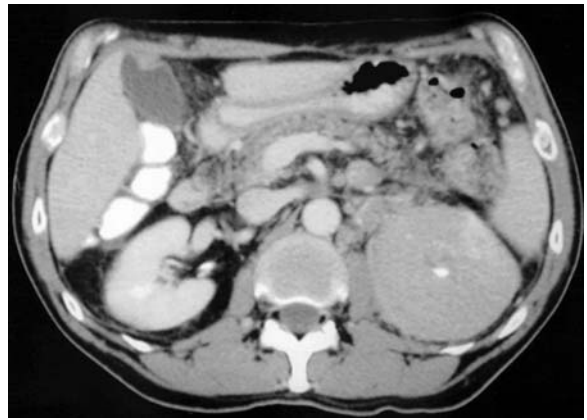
Waldenström macroglobulinemia in a 70-year-old man with renal involvement. Axial contrast-enhanced CT scan of the abdomen shows hypodense left renal mass, which conforms to the contour of the kidney.
